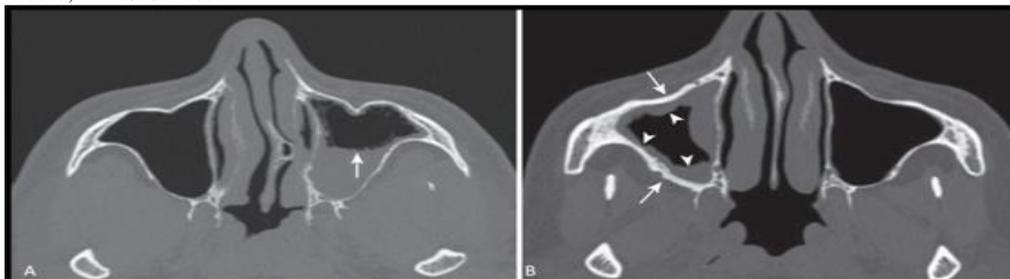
Axial(A) CT PNS (bone window) scan shows mucosal thickening in left maxillary sinus with secretions and air fluid level suggesting acute left maxillary sinusitis. Axial(B) PNS (bone window) scan shows concentric mucosal thickening in right maxillary sinus with bone remodelling of surrounding bony walls of right maxillary sinus (arrows) seen in chronic sinusitis.
